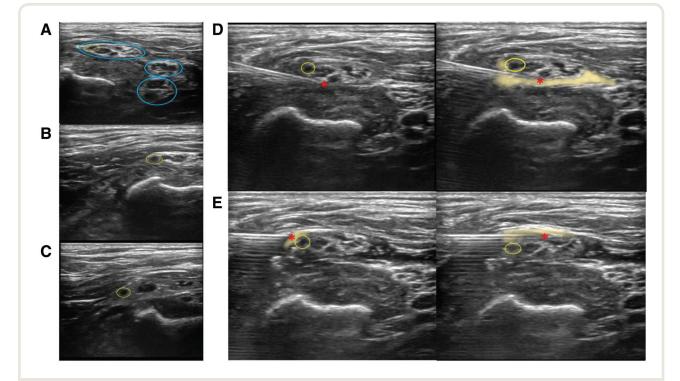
Ultrasonography of superior trunk block. *Yellow ovals* mark suprascapular nerve. *Red asterisks* correspond to needle tip. (*A*) Superior trunk, middle trunk, and inferior trunk are marked with *blue ovals*. (*B*, *C*) As we scan distally, the suprascapular nerve is branching off the superior trunk (*B*) and diving under the omohyoid (inferior belly, *C*). (*D*) Needle is placed posteriorly to the superior trunk as local anesthesia is injected (local anesthetic spread in *yellow highlight*). (*E*) Needle is repositioned anteriorly and laterally as local is injected (see also the video in the Supplemental Digital Content, http://links.lww.com/ALN/B986).
